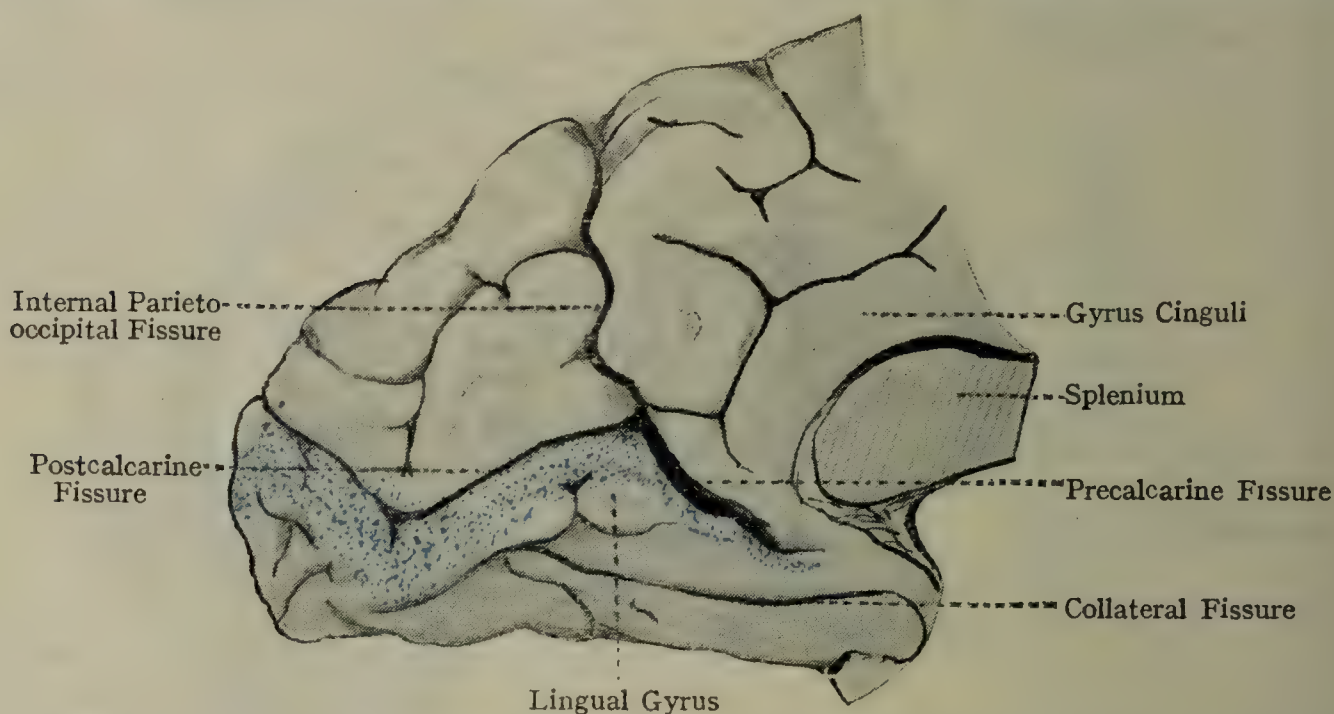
MEDIAL ASPECT OF PARIETO-OCCIPITAL REGION OF LEFT HEMI-SPHERE, TO SHOW INTERNAL PARIETAL OCCIPITAL FISSURE, ANTERIOR AND POSTERIOR CALCARINE.
